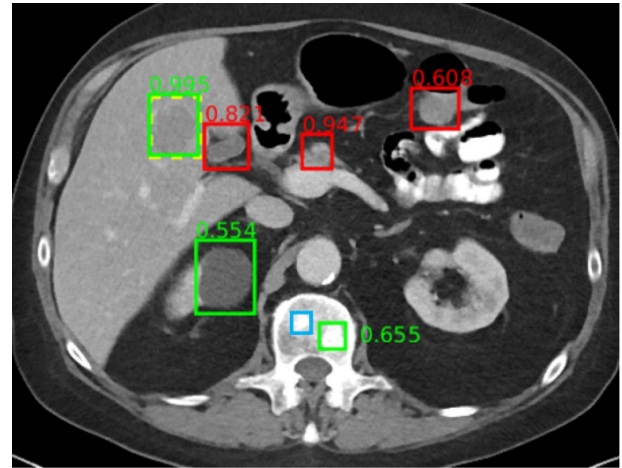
Example universal lesion detector for abdominal CT. In this axial image, through the upper abdomen, a liver lesion was correctly detected with high confidence (0.995). A renal cyst (0.554) and a bone metastasis (0.655) were also detected correctly. False positives include normal pancreas (0.947), gallbladder (0.821), and bowel (0.608). A subtle bone metastasis (blue box) was missed. Reproduced from [186].
